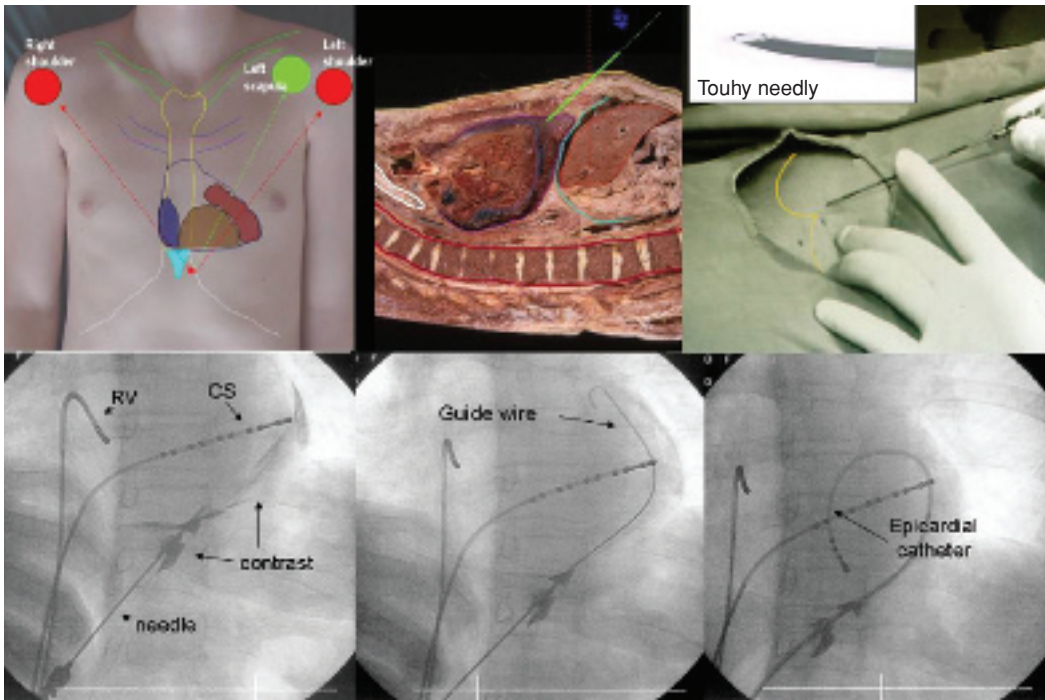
Technique used to insert the mapping catheter in the pericardial space. A regular needle used for epidural anesthesia (shown in detail in the upper left corner) is used during transthoracic puncture according to
